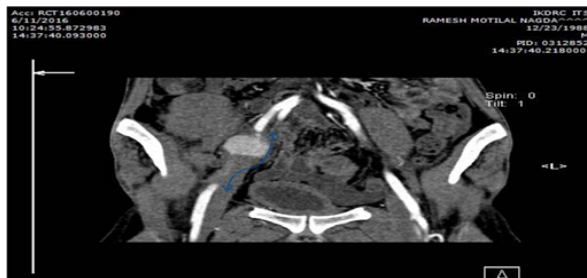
Volume rendering image of CT scan shows anastomotic pseudoaneurysm(blue arrow), graft renal artery (white arrow) and right external iliac artery(black arrow)
